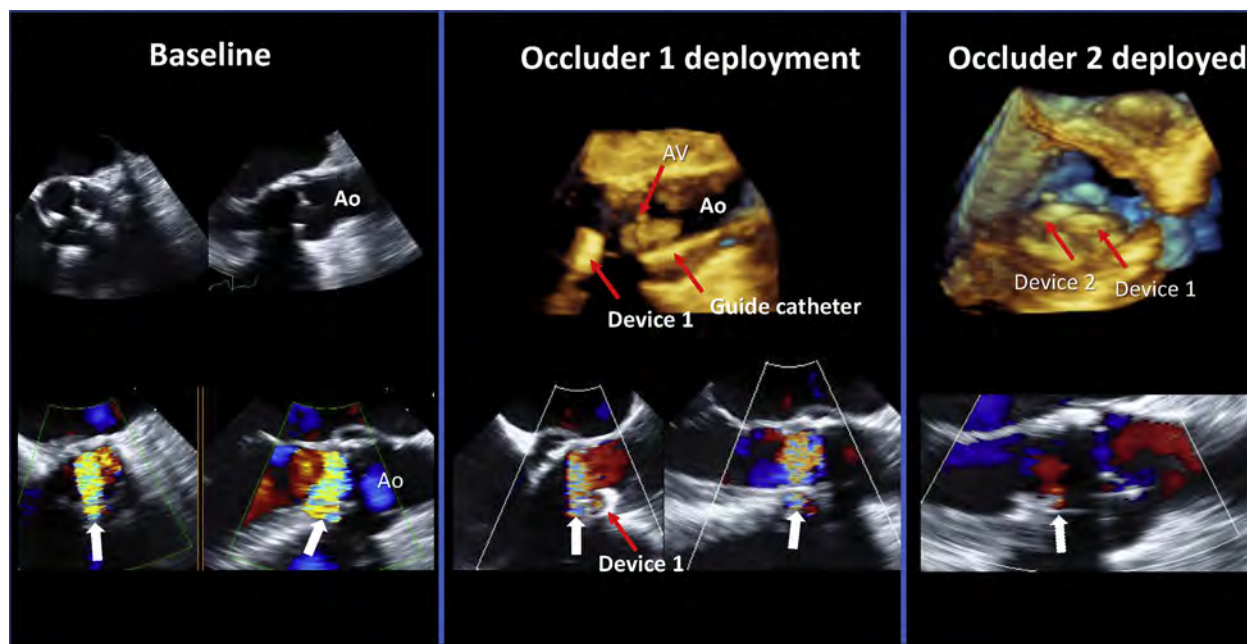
Repair for bioprosthetic aortic paravalvular regurgitation. At baseline: 2D color Doppler depicts very eccentric paravalvular AR evident in both short-axis (*left*) and long-axis (*right*) TEE views (*arrows*). An occluder device is deployed with reduction of color Doppler intensity but with significant residual PVR noted medial to device #1 (*white arrows* in center image, bottom). Occluder device #2 was deployed medial to occluder device #1 with immediate reduction in PVR severity to trace (*white arrow*).
